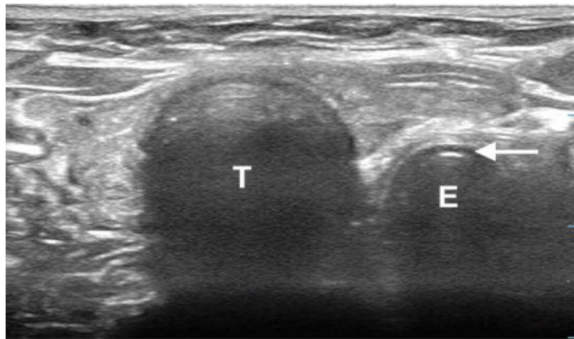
Sonographic image of esophageal intubation
